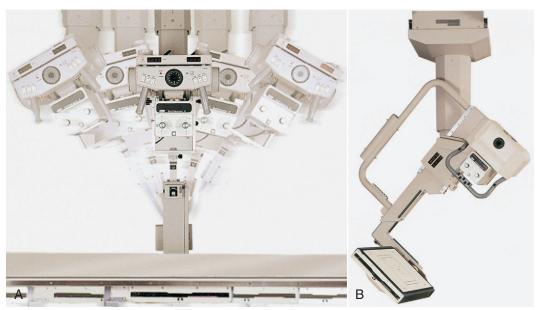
Types of diagnostic x-ray imaging systems. A, Tomographic. B, Trauma.
